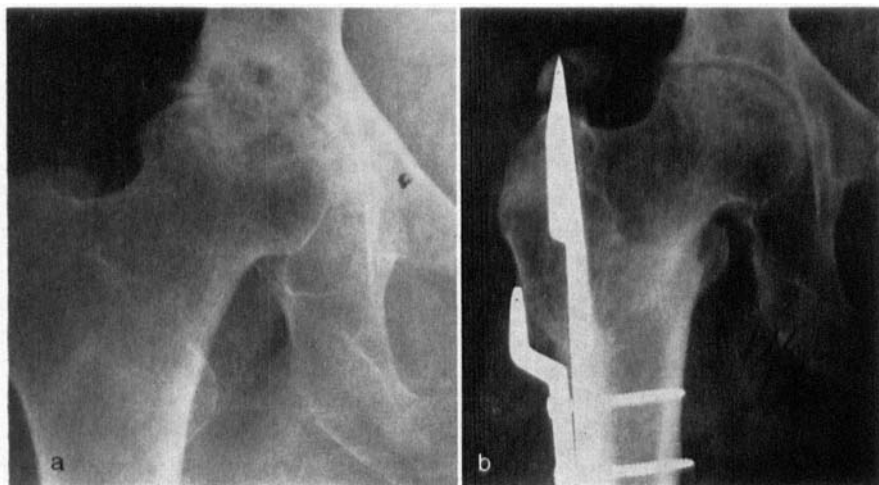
a. Preoperative X-ray. b. X-ray 17 months postoperatively shows a considerably increased joint space, and regression of both cysts and subchondral sclerosis.
